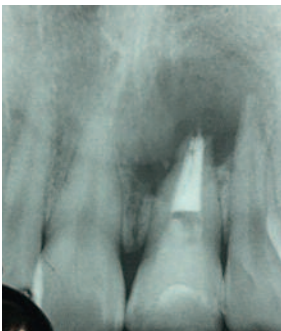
Radiography with placement of Resin-Modified Glass Ionomer.
